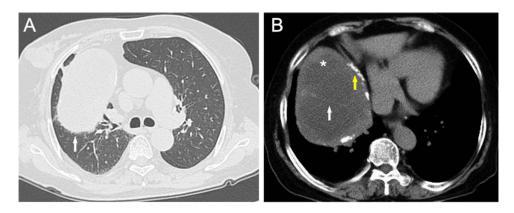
Figure I Enhanced CT showed that the tumor was located in the anterior mediastinum, presenting a mixed mass of cystic and solid, compressing the right lung (white arrow (A), lung window). The tumor boundary was clear ((B), mediastinal window), with arc-shaped calcification shadows (yellow arrow), solid components (asterisk), and internal septa (white arrow).
